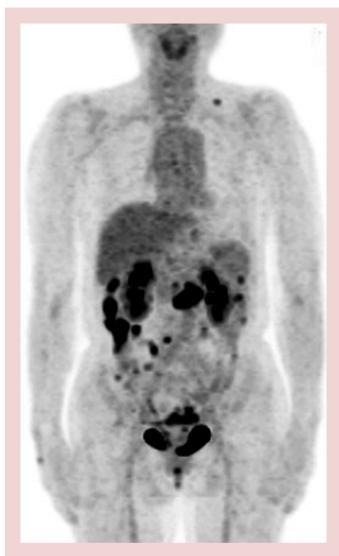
Strong uptake in the distal part of the duodenum in PET/CT
